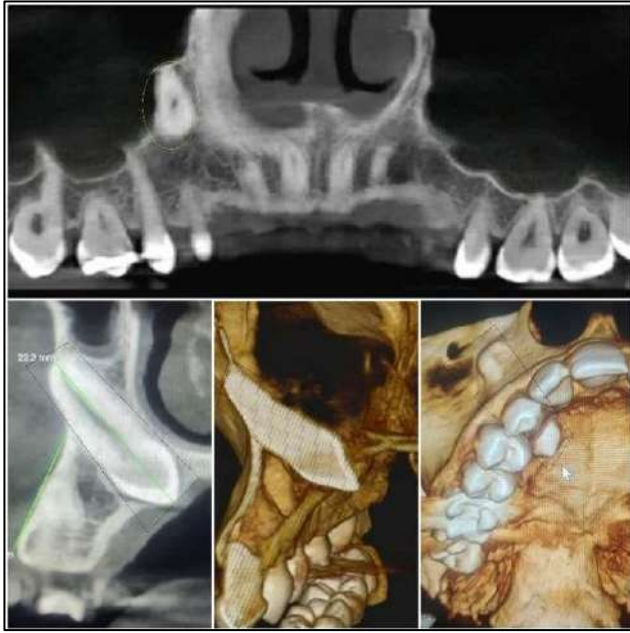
Cone Beam Computed Tomography.
